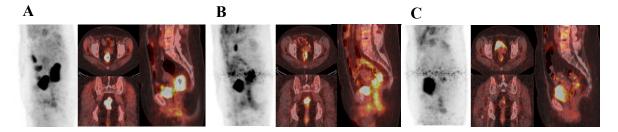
¹⁸F-FDG FDG-PET/CT images in a patient with complete pathological response. (A) Baseline ¹⁸F-FDG uptake in a cT3 lesion (TLG 470.40). (B) Early significant decrease in tumor TLG (TLG 65.86; ΔTLG-early 86%). (C) Late near complete disappearance of the tumor (TLG 14.11; ΔTLG-late 97%). Pathological analysis showed complete tumor regression (ypT0 N0, TRG1). Neither local nor distant recurrence occurred during 83 months of follow-up.
